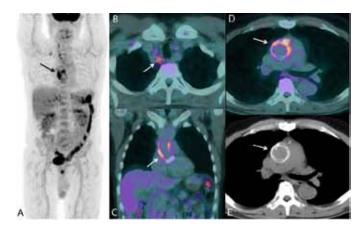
(A) Maximum intensity projection showing pathological mediastinal uptake and no uptake suggestive of septic emboli throughout the rest of the body, (B) Regional analysis of 18F-FDG uptakes point out on mediastinal lymphadenopathies, one on left latero-tracheal posterior area of upper mediastinum, (C, D) Typical uptake pattern around aortic thoracic prosthesis, and (E) Simultaneous computed tomography allow accurate localization.
